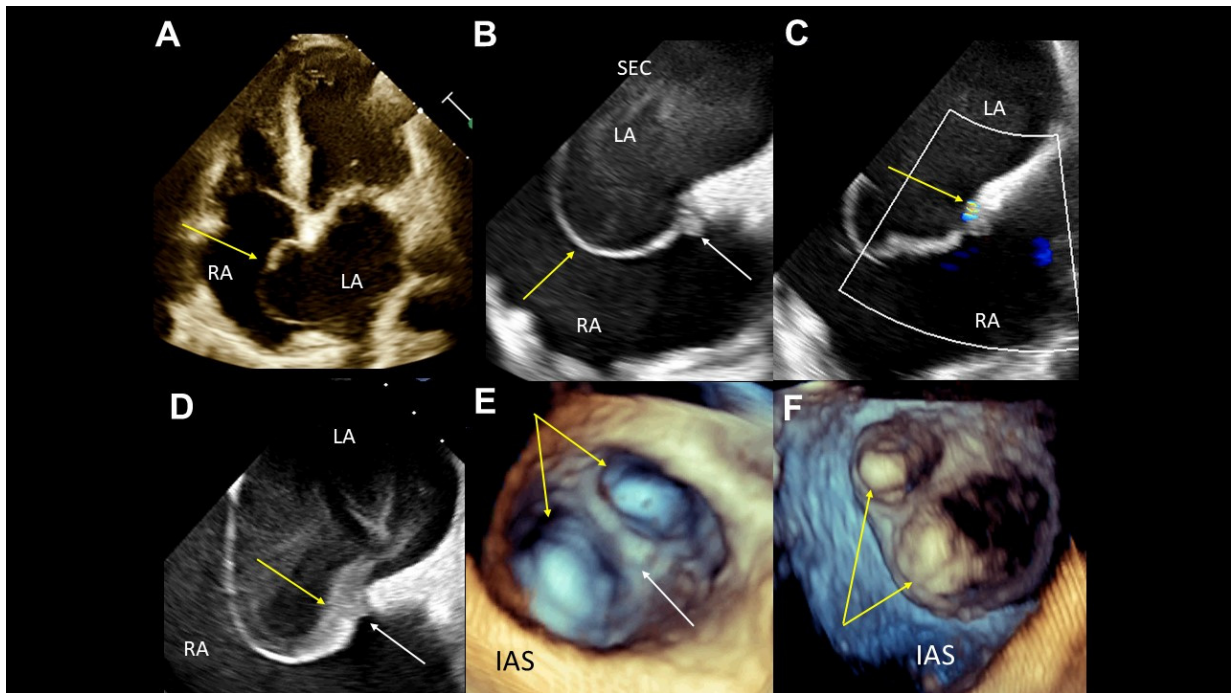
A. Atrial enlargement and bulging of the interatrial septum towards the right atrium (arrow); transthoracic echocardiography; a 4-chamber view. B. A large atrial septal aneurysm (yellow arrow) and a small thrombus in the bent of the PFO channel on the border of the aneurysm (white arrow). C. Small point left to right shunt through the PFO (arrow); 2-dimensional transoesophageal echocardiography, color Doppler. D. Follow-up: more dense blood in the aneurysm cavity (yellow arrow) and a smaller PFO thrombus (white arrow); 2-dimensional transoesophageal echocardiography. E. An unusual morphology of the atrial septal aneurysm: two recesses separated by a septum (arrows), a view from the left atrium. F. Atrial septal aneurysm — view from the right atrium; 3-dimensional transoesophageal echocardiography
